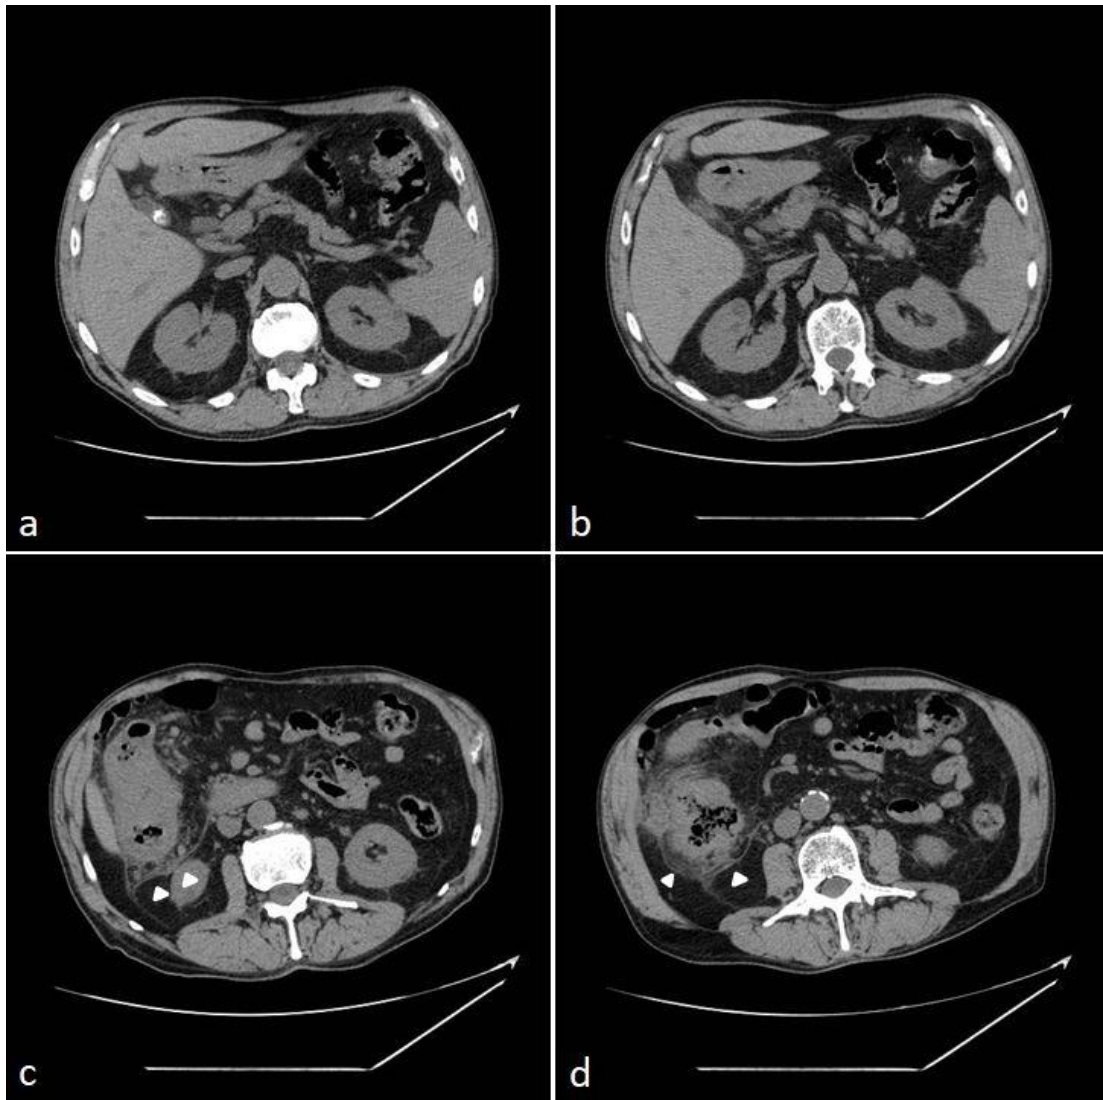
Preoperative CT scan. a-b) in this clinical case is not possible radiological identification of fascia of fredet. c-d) the same patient with clear detecting of Toldt's fascia and Gerota's fascia.
